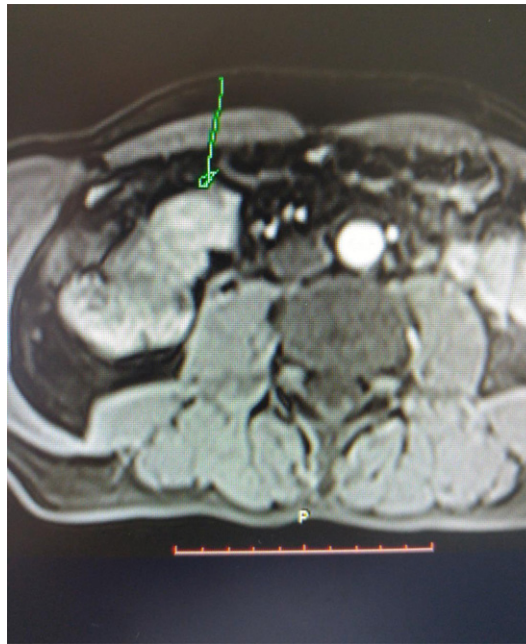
Abdominal MRI showing desmoplastic reaction in a patient with CS secondary to a small intestine NEN.
